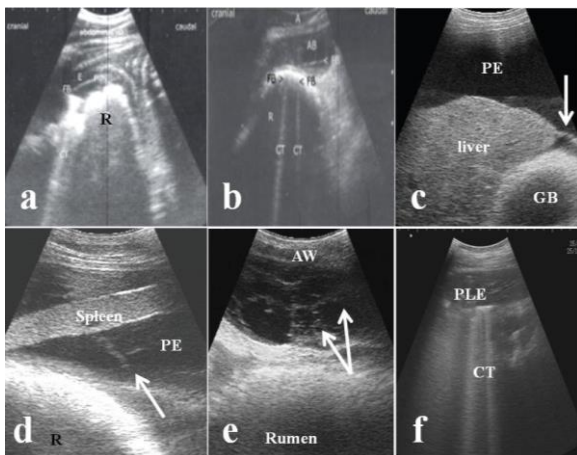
a) Ultrasonogram of the reticulum (R) of a hardware diseased buffalo showing uneven surface of the reticulum and echogenic foreign body (FB) with a comet tail artifact (CT). F: fibrin; E: exudates. b) Ultrasonogram of the reticulum (R) of a hardware diseased buffalo showing hypoechoic abdominal abscess (AB) and two echogenic foreign objects (FB) with comet tail artifacts (CT). Ultrasonograms of local peritonitis showing corrugated thick reticulum and echogenic fibrin strands (arrows) interspersed with anechoic peritoneal exudates (PE) between the reticulum and liver (c), reticulum and spleen (d) and reticulum and abdominal wall (e). (f) Ultrasonogram of traumatic pleuropneumonia showing hypoechoic exudates in the pleural cavity (PLE), absence of reverberation artifact, presence of echogenic foreign bodies, comet tail artifacts (CT) and hepatized lung. GB: gall bladder, AW: abdominal wall. Sources: a and b: Abdelaal and Floeck (2015); c, d and e: Imran *et al.* (2011).
